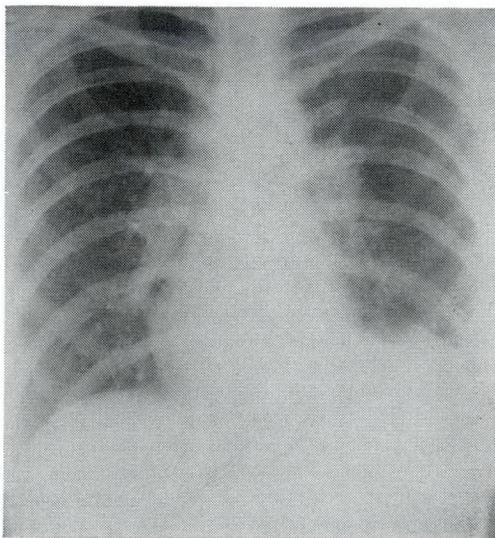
Case 2—bronchogenic cyst. Postoperative chest radiograph.
